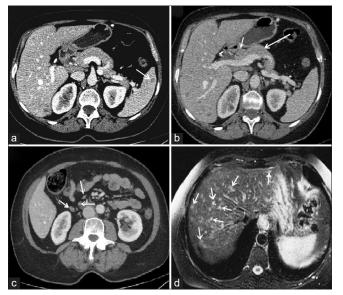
(a) In this CT scan, a hypodense lesion in the spleen is clearly evident (arrow). (b) This CT scan shows a lymph node resting on the cephalic portion of pancreas (short arrow). Pancreas (long arrow). (c) CT shows some perirenal and perivascular lymph nodes (arrows). (d) Abdominal MRI. Axial plane view shows hyperintense, subcentimetric liver lesions spread throughout the parenchyma (arrows). CEUS: Contrast enhancement ultrasound, CT: Computed tomography
